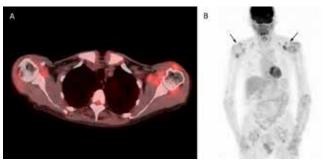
(A) Fused axial 18FDG-PET/CT image demonstrating periarticular radiotracer uptake in both shoulder joints with greater involvement on the left. (B) Coronal maximum-intensity projection 18FDG-PET/CT attenuation corrected image demonstrating FDG uptake in the periarticular regions (arrows) consistent with amyloid arthropathy.
